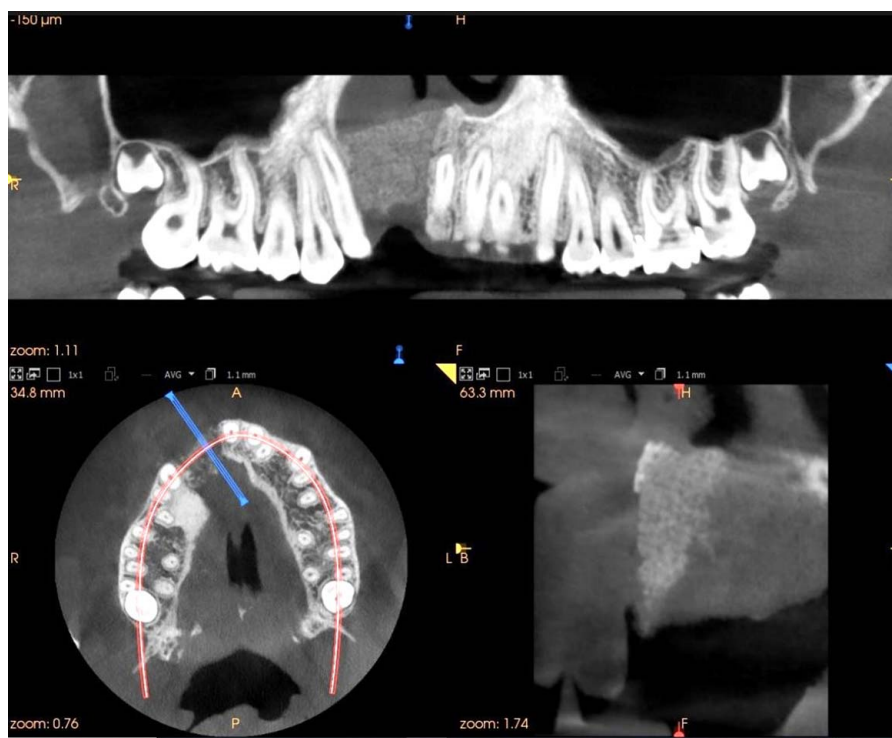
Postoperative cone-beam computed tomography scan.
